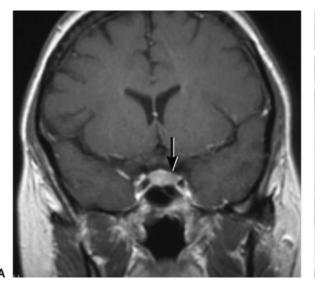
(Case 3) (A) T1-weighted coronal 1.5T MRI with contrast shows slight hypointensity on the left side of the sella (arrow) consistent with a left-sided pituitary mass. (B) T1-weighted 3T coronal MRI with contrast shows marked differentiation of the hypointense tumor (arrow) and surrounding normal gland.
